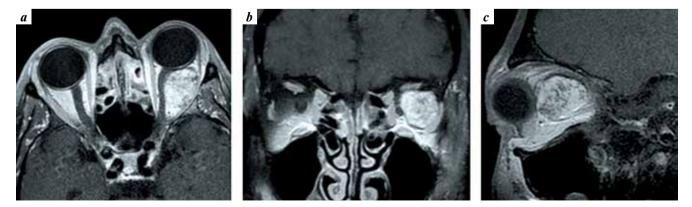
Cavernous hemangioma of the left orbit in patient T. Preoperative contrast-enhanced T1-weighted magnetic resonance imaging: a-axial view; b-frontal view; c-sagittal view. Cavernous hemangioma in the lateral part of the left orbit intensively accumulates contrast and displaces the left optic nerve medially
